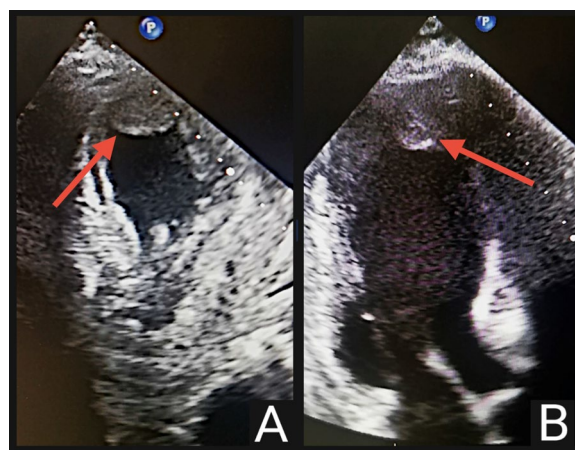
The transthoracic echocardiography image of patient 1; the thrombus is marked with arrows, modified four-chamber cardiac view (A) and three-chamber cardiac view (B) projections
